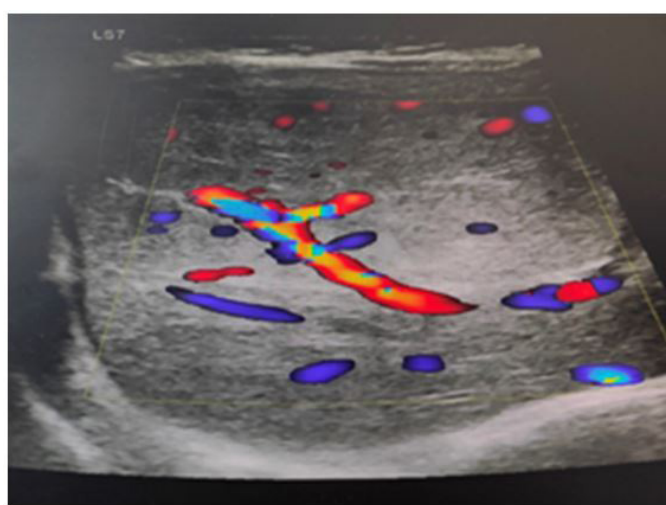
Doppler mode liver ultrasonography image
